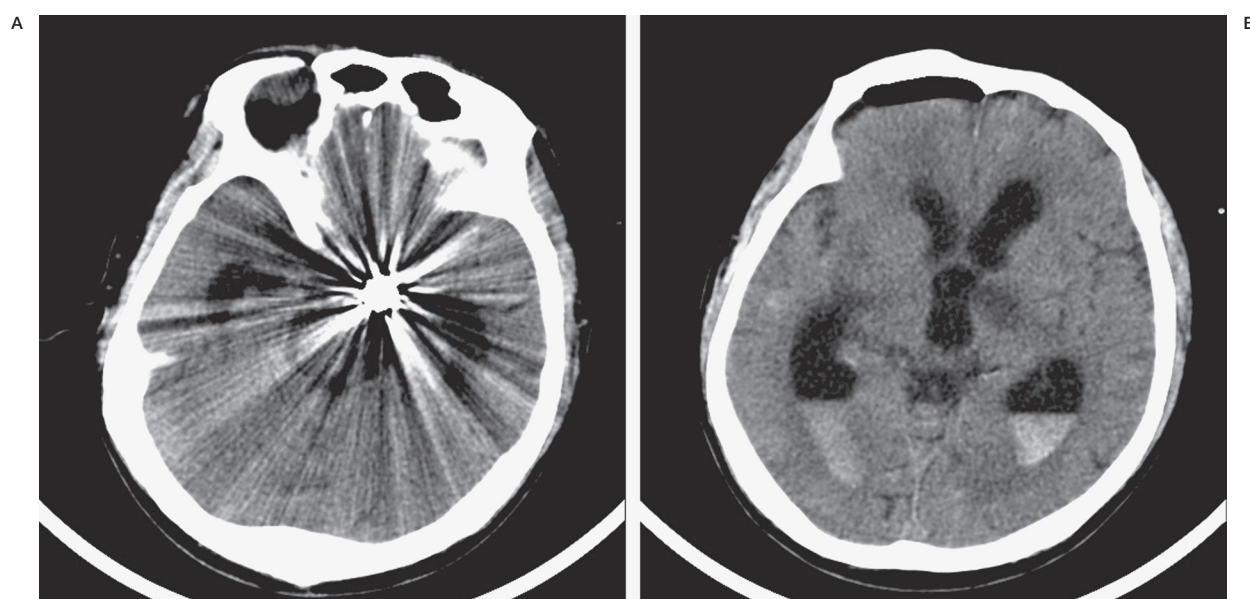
A,B) CT scan 4 days after coiling indicating tuberothalamic artery infarction.
